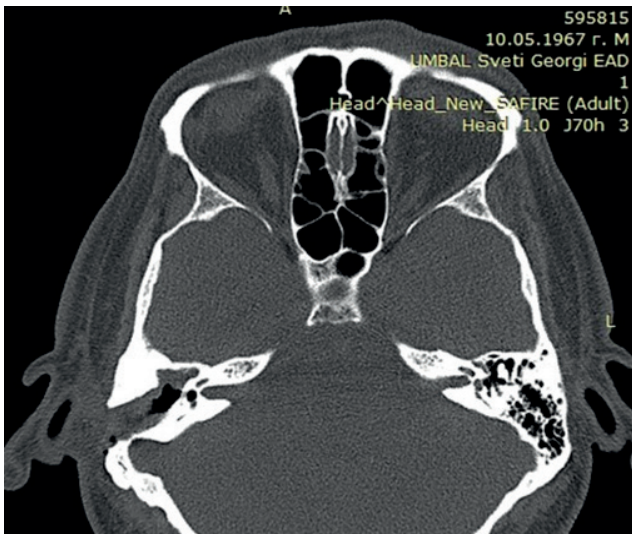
CT image of the right lateral semicircular canal fistula.
